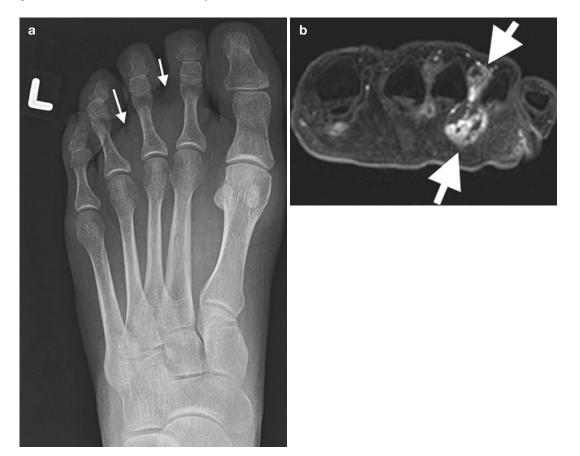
(a) AP left foot radiograph in a patient with rheumatoid arthritis and soft tissue prominence on the second and third interspaces (*arrows*) and (b) axial T1FS
